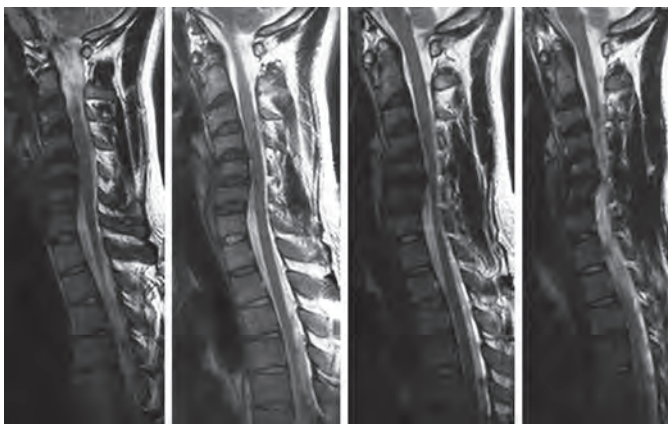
MRI (T2-weighted images) showing posterior annular bulge at C4/C5 with straightening of cervical spine from C1 to C4
